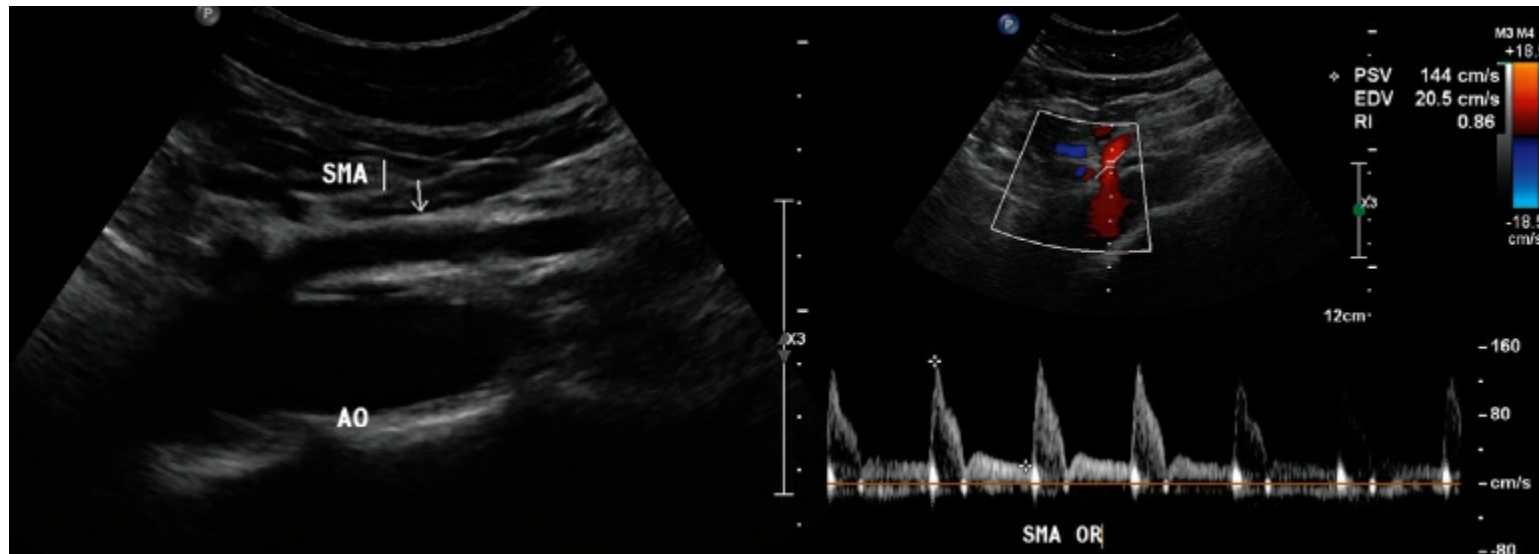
Mesenteric duplex ultrasound of a normal aorta and SMA that demonstrates moderate to high arterial resistance in the SMA, with low diastolic flow and slight flow reversal during fasting states. AO, aorta; SMA, superior mesenteric artery; PSV, peak systolic velocity; EDV, end-diastolic velocity; RI, resistive index; OR, origin.
